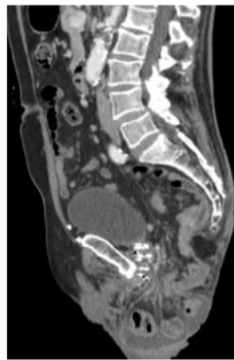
CT abdomen/pelvis with contrast pre- and post-perineal hernia repair with mesh
